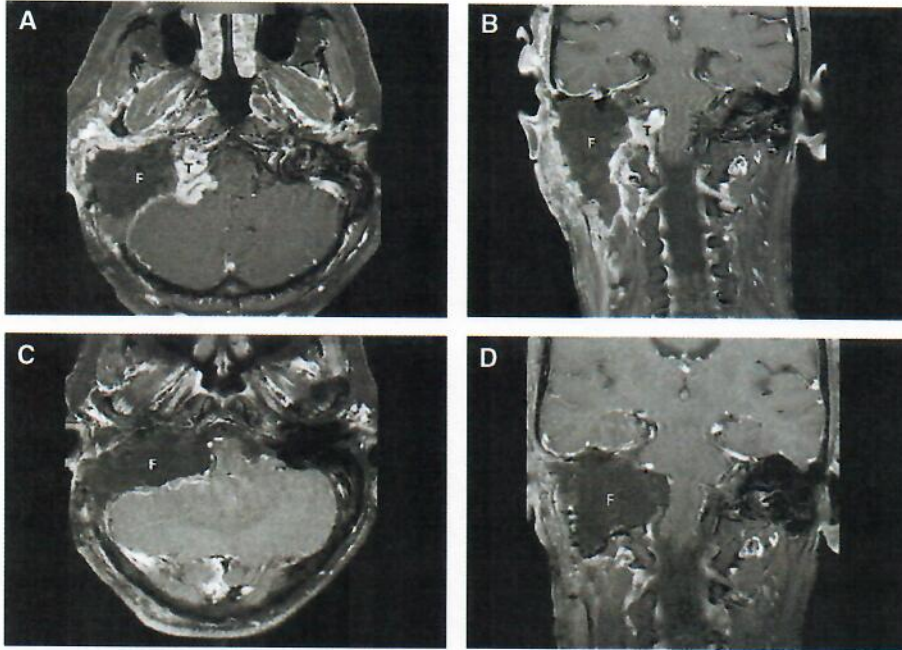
Imaging. (A and B) MRI, axial, and coronal views after the first-stage surgery. The residual intradural tumor is noted. The surgical defect is filled with abdominal fat. (C and D), MRI, axial, and coronal views after the second-stage surgery. After the surgery, there is no residual tumor. F, fat; T, intradural tumor.
